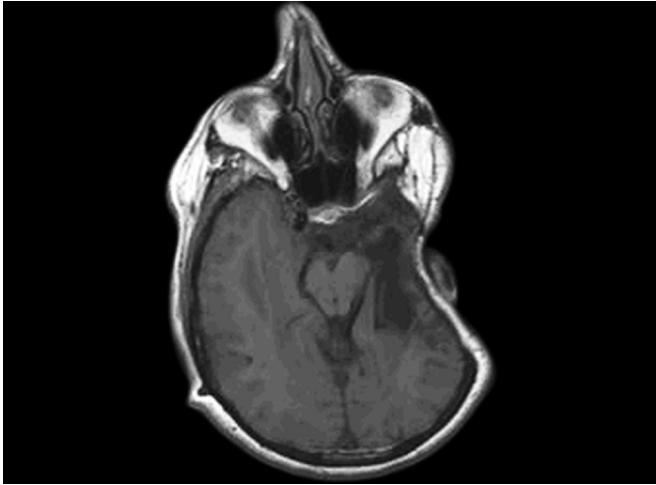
Magnetic resonance imaging (MRI) showing a portion of resection of a patient with a grade 2 chondrosarcoma. Gross total tumor resection was accomplished.
